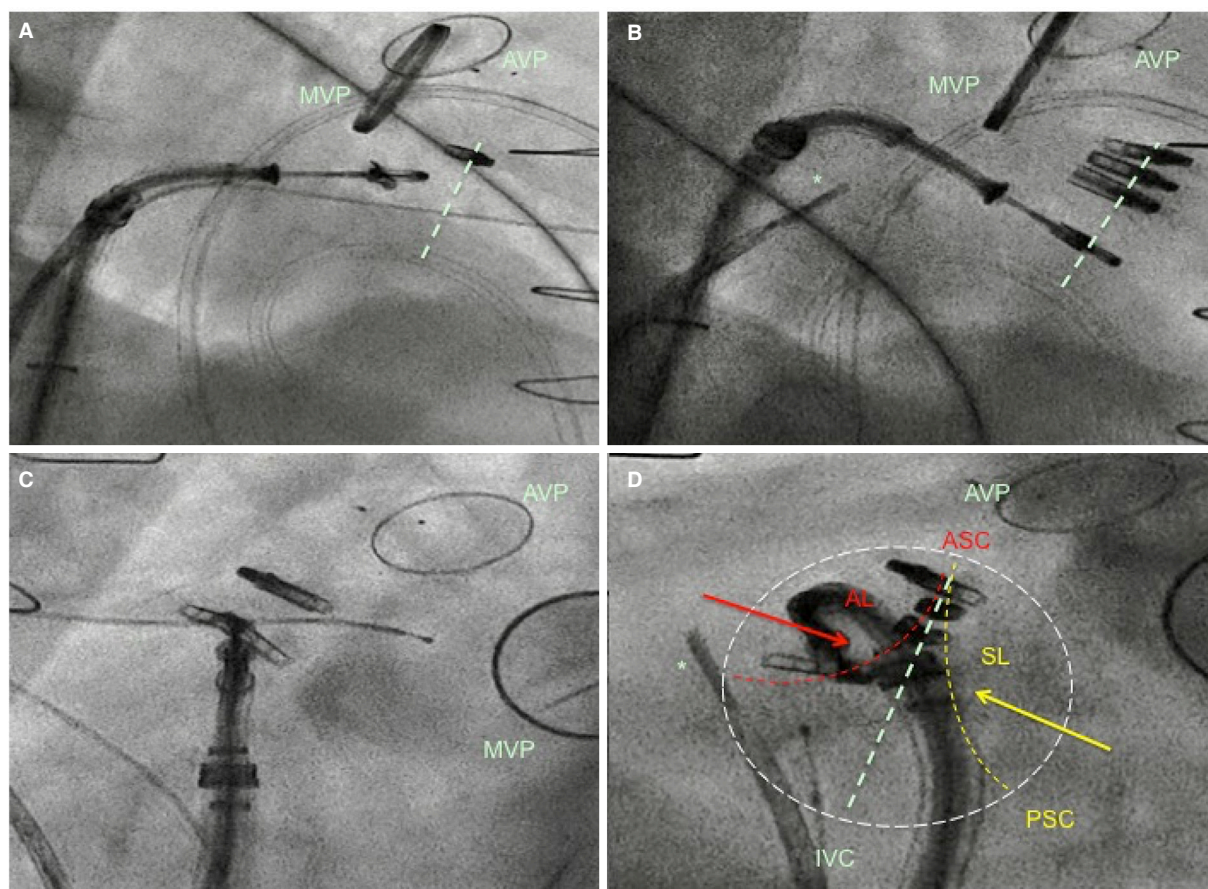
A and B: show two right fluoroscopic 2-chamber views during percutaneous tricuspid MitraClip™ procedure, useful to advance the catheters towards the tricuspid valve and to calculate the trajectories to address the targeted commissure. Light green dotted line traced in Panel A-B is the hypothetical line of coaptation between the anterior and the septal leaflet; C and D: show two en-face fluoro views during the same procedure, useful to guide catheter navigation within the valve area and to position the MitraClip™ in the antero-septal commissure (ASC), closest to the tricuspid annulus. AL is anterior leaflet (dotted line); PSC (yellow) posteroseptal commissure with SL septal leaflet (dotted line). Light green dotted line traced in Panel D is the line joining the aortic valve (ASC) and the inferior vena cava, reflecting the theoretical line of coaptation between the anterior and the septal leaflet. Arrows indicate traction forces on the leaflets done by the edge-to-edge percutaneous repair. The white dotted circle depicts the theoretical tricuspid ring. *Intracardiac echocardiography (reprinted with permission from Pozzoli *et al.* [47]). AVP: aortic valve prosthesis; MVP: mitral valve prosthesis
